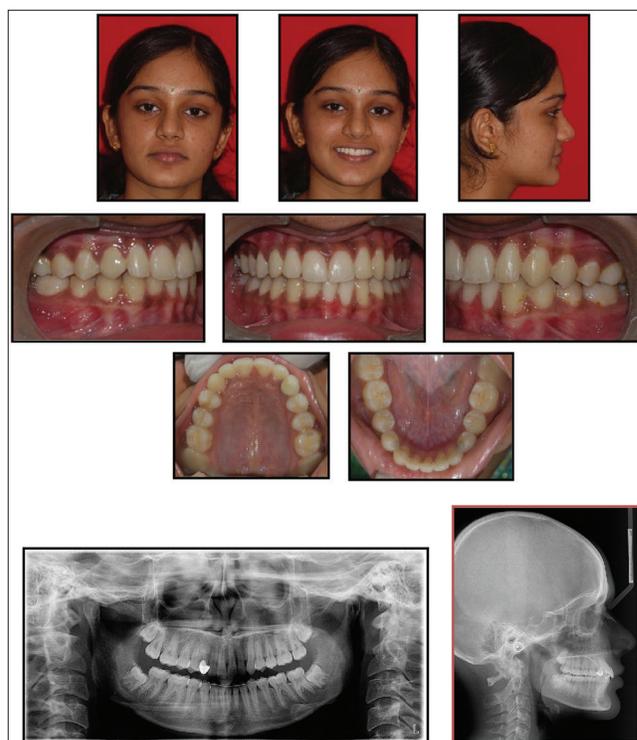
Posttreatment extraoral and intraoral photographs and radiographs
